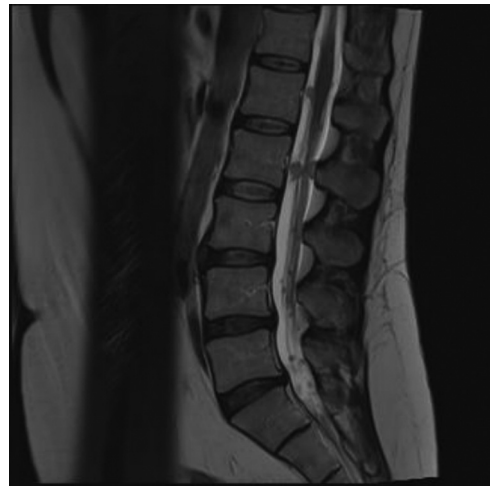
Sagittal post contrast MRI T1 of the lumbar and lumbosacral spine showing dural lesion at the level of L1 until conus medullaris.
